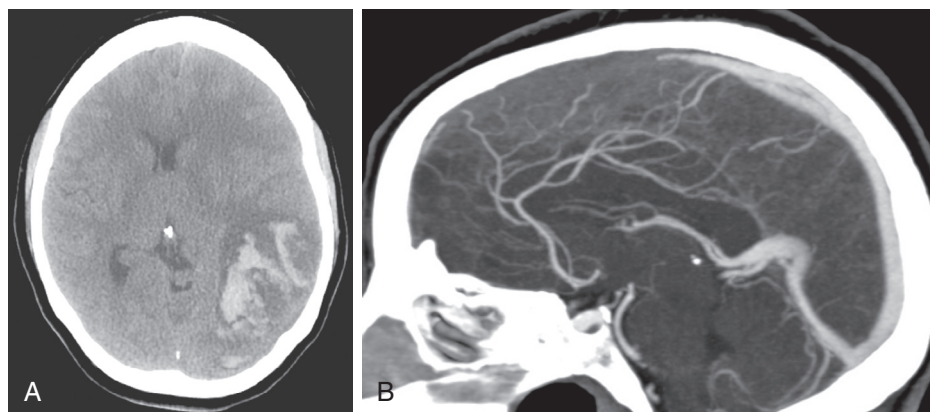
■ Case example of superior sagittal sinus thrombosis giving rise to an intracerebral hemorrhage. A, CT brain showing a brain hemorrhage and brain edema. B, CT venogram showing occlusion of the anterior portion of the superior sagittal sinus. CT, computed tomography.
